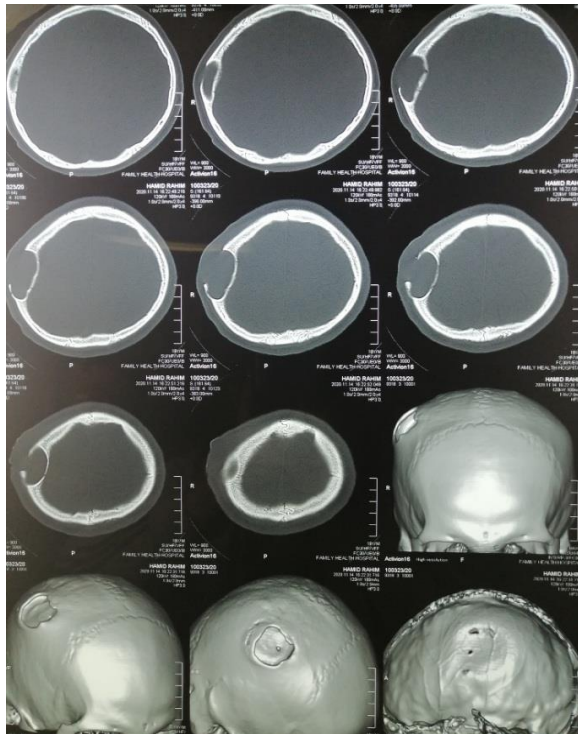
CT skull bone window with 3D reconstruction, Showing lytic expansile lesion in right parietal bone with thinned, intact inner table and partially eroded outer table.
